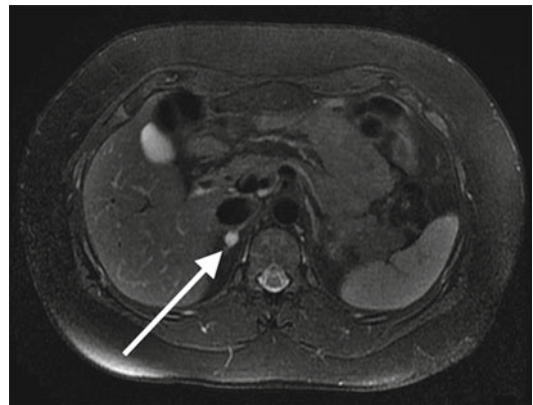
Twenty-six-year-old woman with von Hippel-Lindau syndrome. Axial T2-weighted image demonstrates a small, T2 bright mass (arrow) within the right adrenal gland. This was a pathologically proven pheochromocytoma. This patient had previous resection of the left adrenal gland, which was also a pathologically confirmed pheochromocytoma
